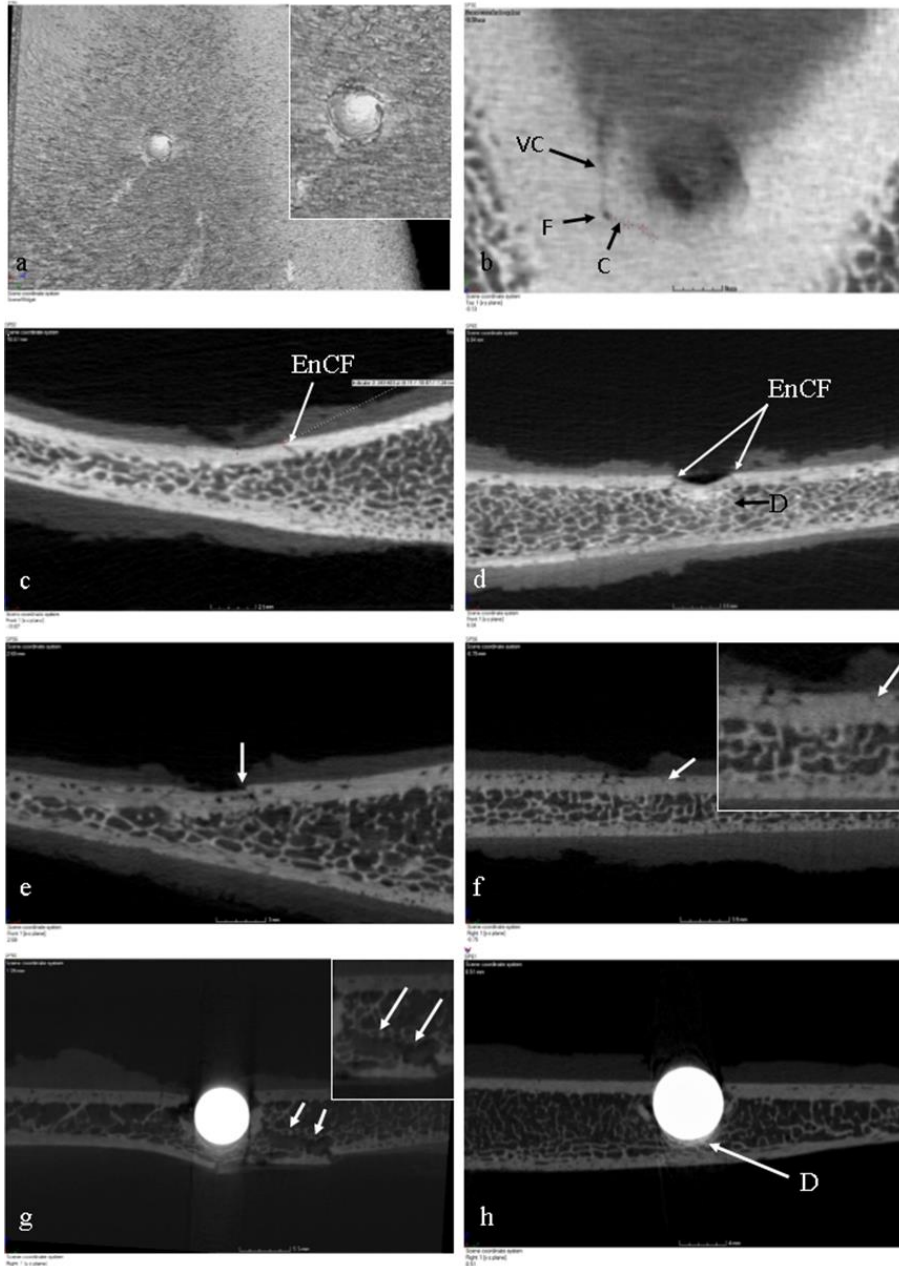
μ -CT cross-sections of compressed cortical discs and two projectiles embedded *in-situ*; a, example of compressed disc of cortical bone at the impact site; b, ring crack (C) originating from nutrient foramen (F) with vascular canal (VC) running vertically; c, transverse section of ring crack in b showing incipient conoidal wound formation with the presence of an angulated entry cortical fracture edge (EnCF); note minimal compression of the cortex under the impact point; d, example of cortical disc showing more extensive compression with some densification (D) of the trabecular cells; note bilateral angulation of the EnCF and crack opening adjacent to the compressed disc; e, downward movement of the lateral portion of a compressed cortical disc in relation to the EnCF, indicating a mode 2 (in -plane shear) failure component; f, example of mode 1 tensile failure without evidence of in plane shear; g, cross-section of projectile embedment with projectile *in-situ*; wound exhibits bilateral angulation of the EnCF with the cortical disc having fractured in the mid-line and displaced laterally; note formation of a conoidal wound volume despite lack of projectile exit, tensile fracture of inner cortical plate and evidence of crack hopping one cell edge to another (white arrows); h, cross-section of second projectile embedment showing bilateral angulation of the EnCF, midline fracture of the cortical disc and densification (D) of the trabecular cells
